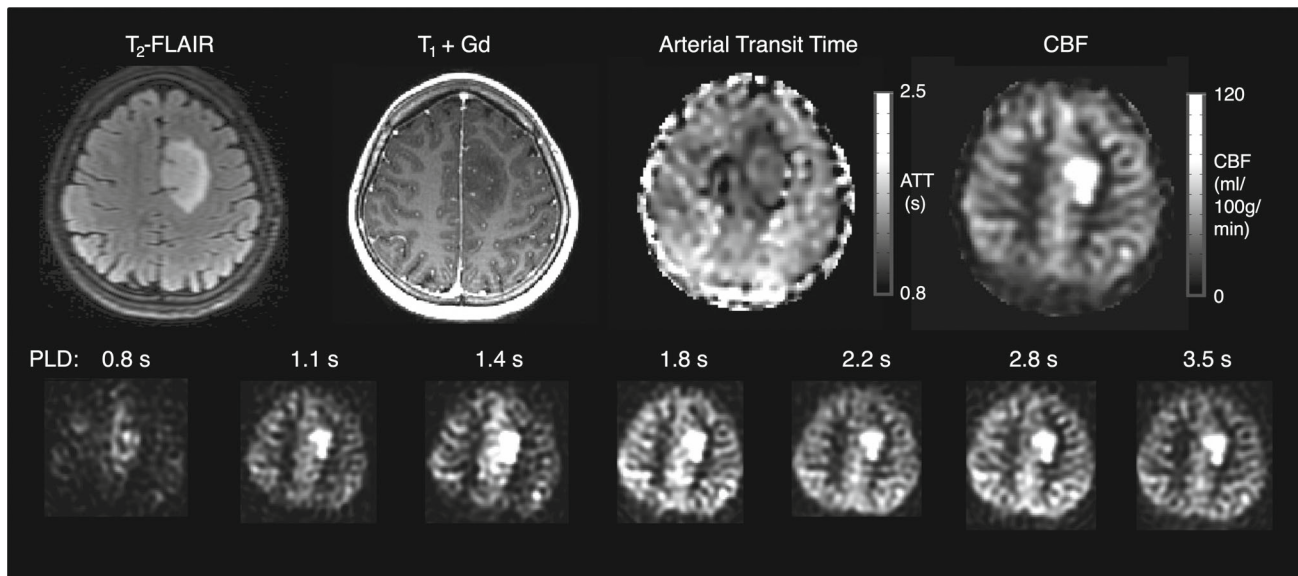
An example time-encoded multi-timepoint PCASL acquisition in a low-grade diffuse glioma (oligodendroglioma, WHO grade 2). Top row: The extent of the tumor can be seen in the T₂-FLAIR (hyperintense region). The T₁ + Gd shows no enhancement. The calculated PCASL CBF and ATT maps indicate an area of high perfusion with short arrival time within the tumor region, in part due to large intravascular signal contributions present in these data which were not modeled here. This is consistent with the finding that oligodendroglioma tend to be highly perfused and have high blood volume with irregular, although non-leaky, vasculature. Bottom row: perfusion-weighted images at each of the acquired PLDs.
